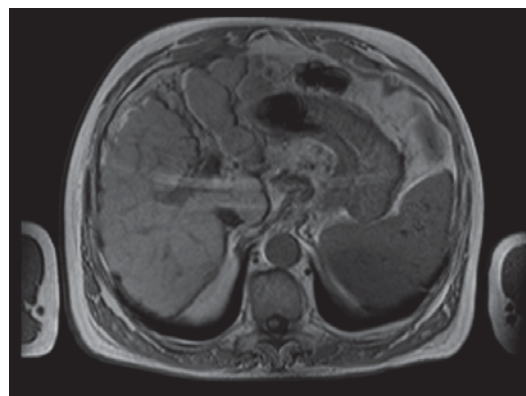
Abdominal magnetic resonance imaging showed normal sized, inhomogeneous, macronodular liver.
